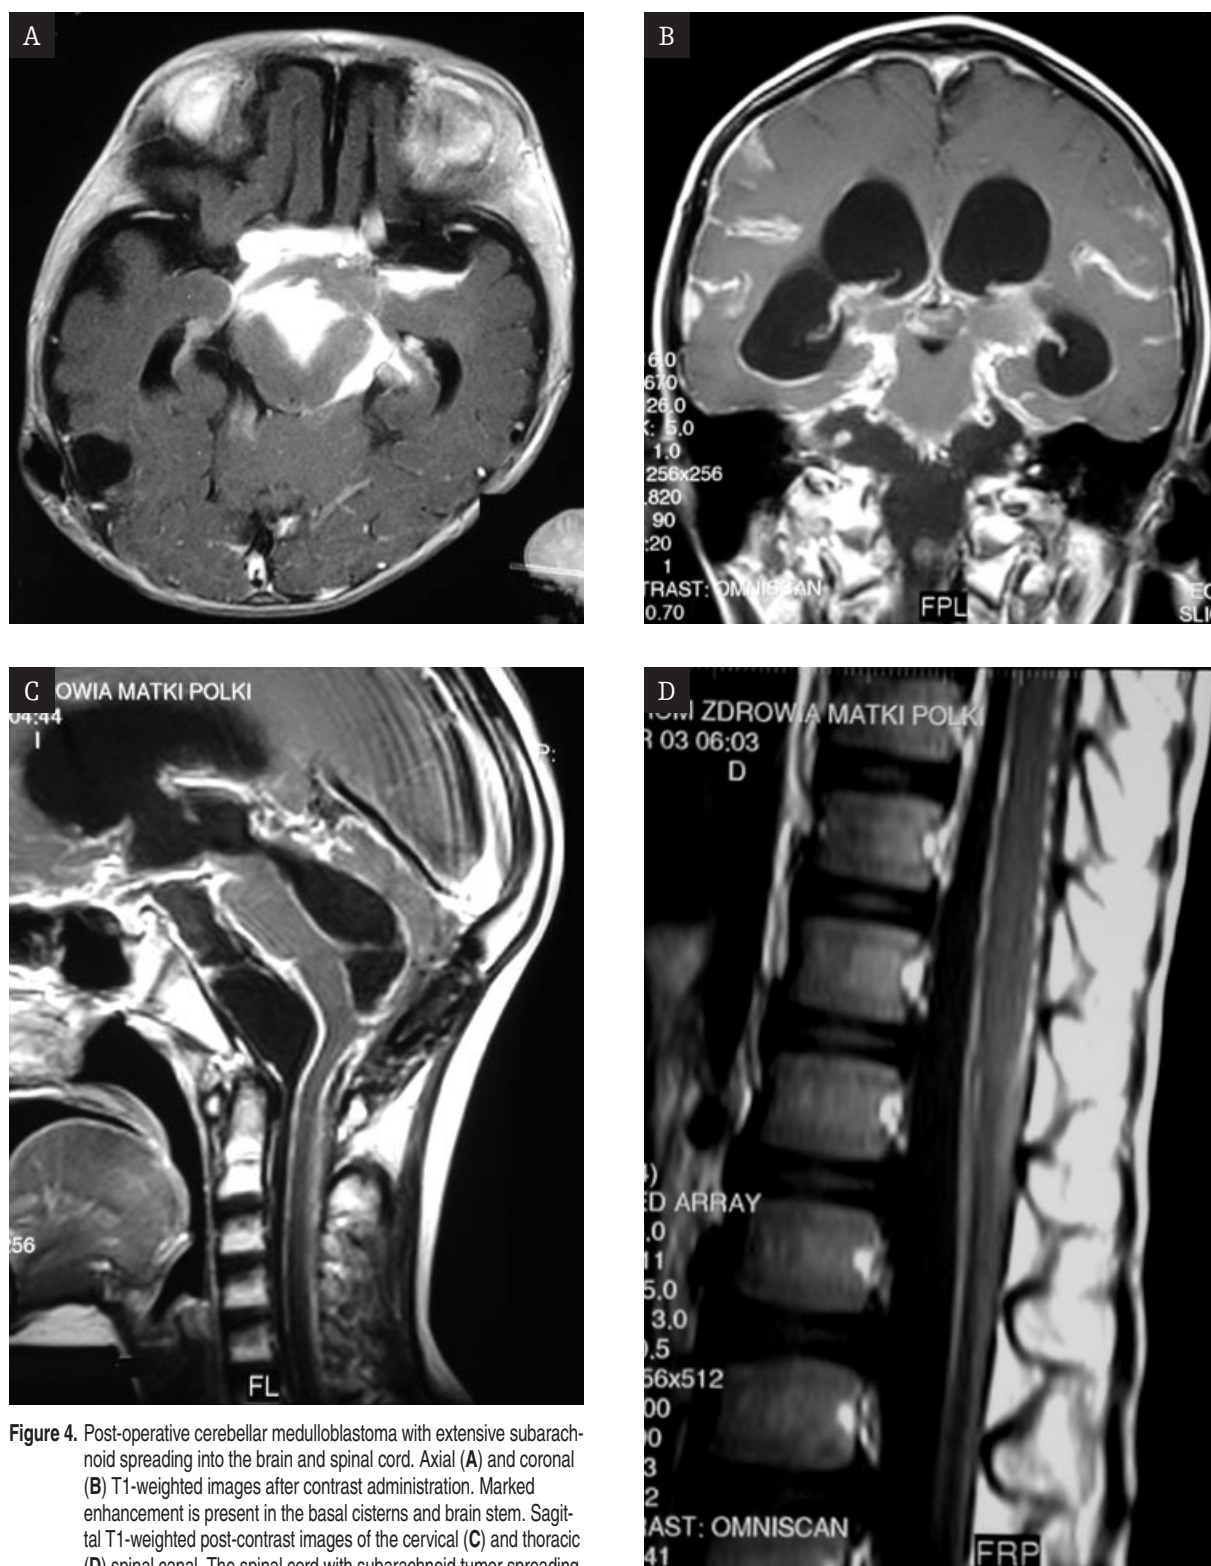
Post-operative cerebellar medulloblastoma with extensive subarachnoid spreading into the brain and spinal cord. Axial (A) and coronal (B) T1-weighted images after contrast administration. Marked enhancement is present in the basal cisterns and brain stem. Sagittal T1-weighted post-contrast images of the cervical (C) and thoracic (D) spinal canal. The spinal cord with subarachnoid tumor spreading.
